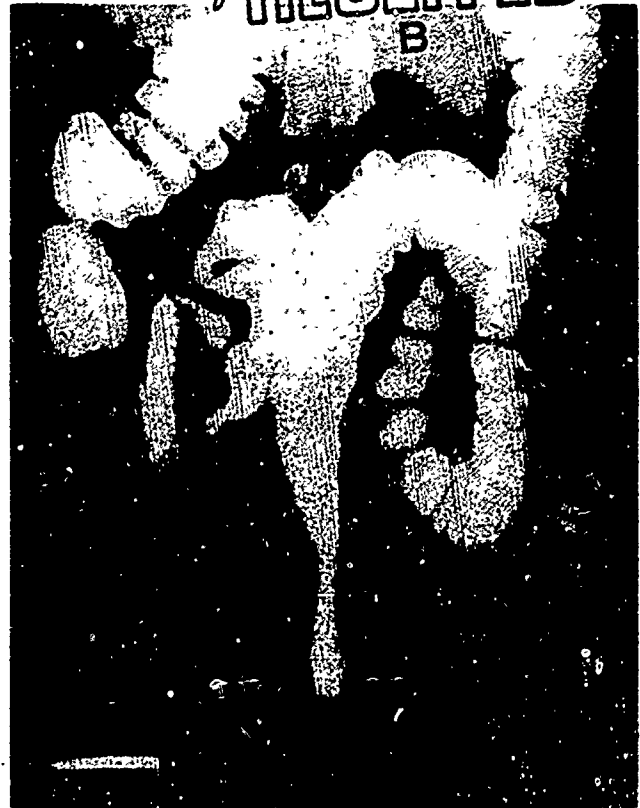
Radiograph made after barium enema showing an elongated and narrowed rectum but no mucosal irregularity.
